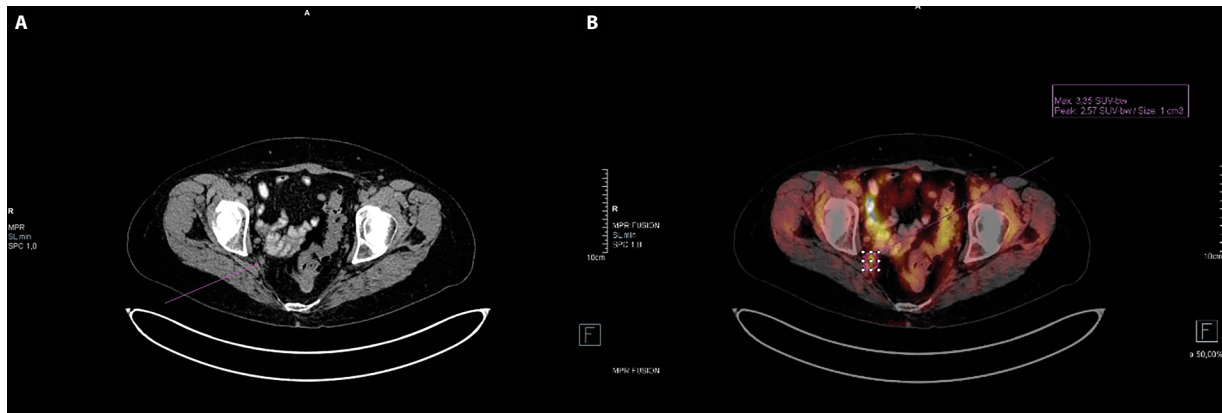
Example of TP findings of positron emission tomography (PET/CT) scan; A. Transaxial slice; B. 3D maximum intensity projection (MIP)
